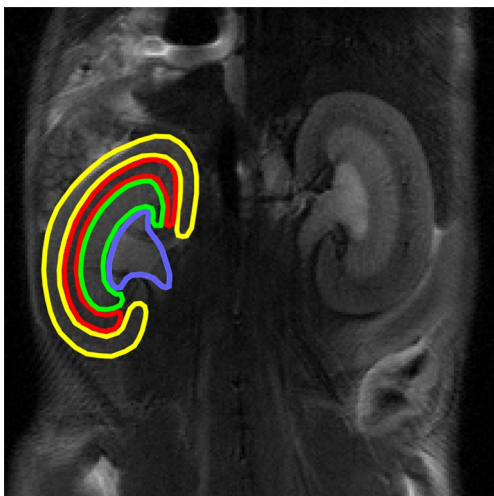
Placement of ROIs on T2-weighted images obtained from MRI. For ROI placement four anatomical layers of kidney, cortex (yellow), OSOM (red), ISOM (green), and IM + P (blue) were used. ROI, region of interest; MRI, magnetic resonance imaging; OSOM, outer stripe of outer medulla; ISOM, inner stripe of outer medulla; IM + P, inner medulla and pelvis.
